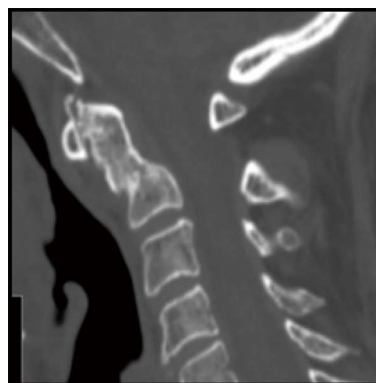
Computed tomography-scan performed at the end of 3 mo of anabolic therapy with Teriparatide confirming a complete fusion of the fracture with acceptable alignment.
